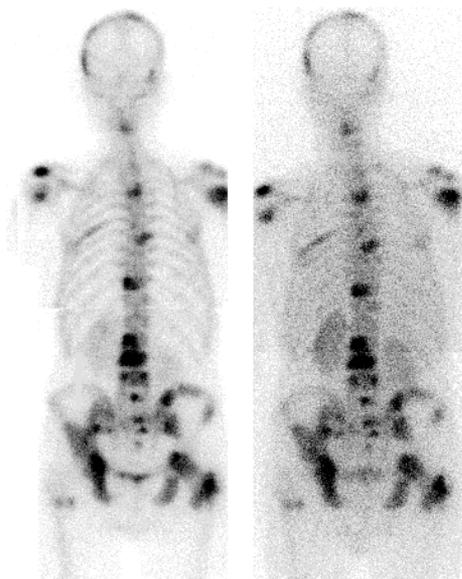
Skeletal scintigraphy 3 hours after injection of 600 MBq (16.2 mCi) ^{99m}Tc-HDP (Left); or 24 hours after injection of 1295 MBq (35 mCi) ¹⁸⁶Re-HEDP (Right). Biodistribution of the radiopharmaceutical and localisation of the metastases correlates perfectly between the 2 images in this patient, with hormone-refractory prostate carcinoma
